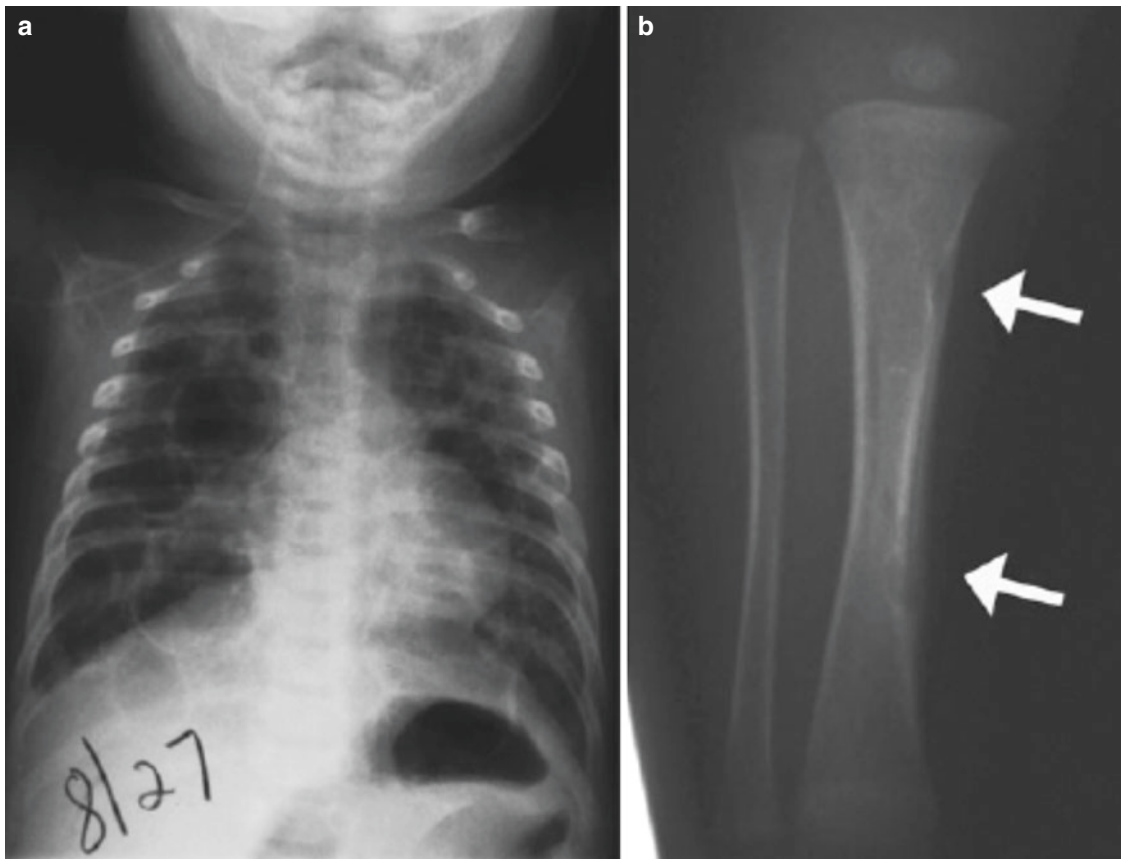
Disseminated form of Langerhans cell histiocytosis in a 3-year-old boy involving the pulmonary and musculoskeletal systems. (a) Frontal chest radiograph shows extensive lucent cysts throughout
